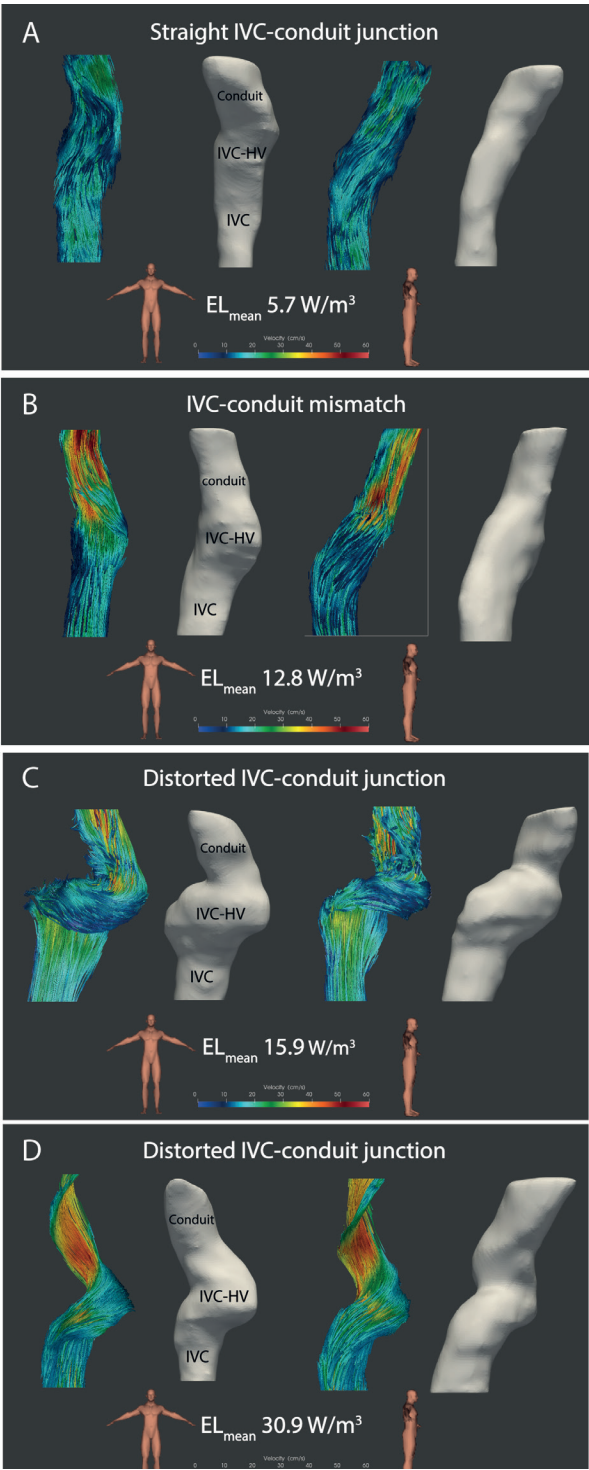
(opposite) Pathline images of 4D flow MRI derived blood flow in the IVC-conduit junction, excluding the HVs, is shown for 4 representative cases. Normalized mean energy loss values (W/m^3) are reported.
